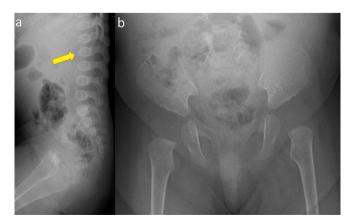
Plain radiographs of the lumbar spine (a) and pelvis (b) at 8 months of age show mild spondylar dysplasia and iliac deformity. The lumbar vertebral bodies are rounded. Anterior bone projection is seen at L2 (arrow). The iliac wings are flared. The distal ilia are constricted along with steep acetabular angles.
